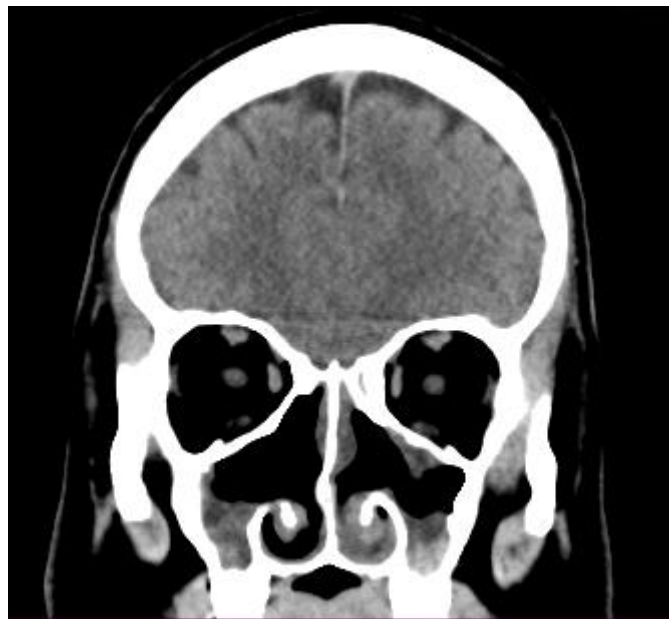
Postoperative CT scan (coronal slice) after pan sinusotomy due to CRSwP.
